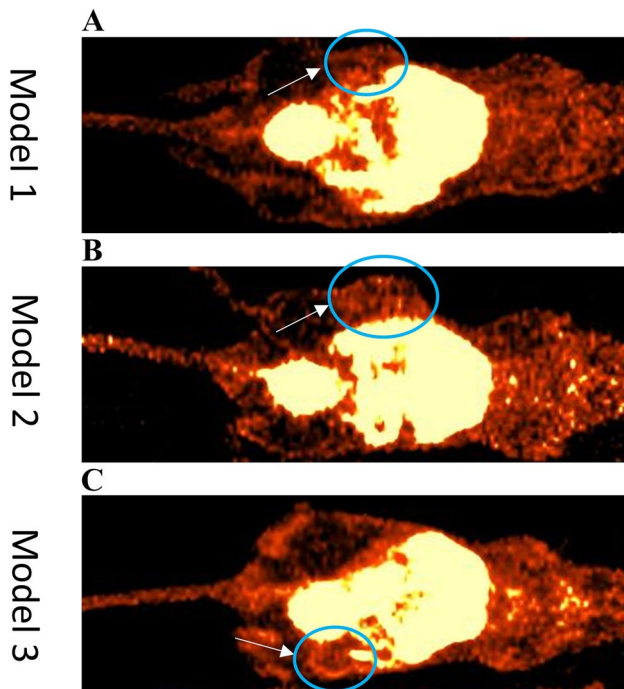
^{64}Cu -uPAR-PET/CT 1 h after tracer injection in three OSCC PDX models. White arrows indicate tumor lesions, all of them located in the flank. A Model 1 with low diffuse uptake. B Model 2 with high diffuse uptake. C Model 3 showing high uptake with hot spots and rim enhancement around cystic tumor lesion
